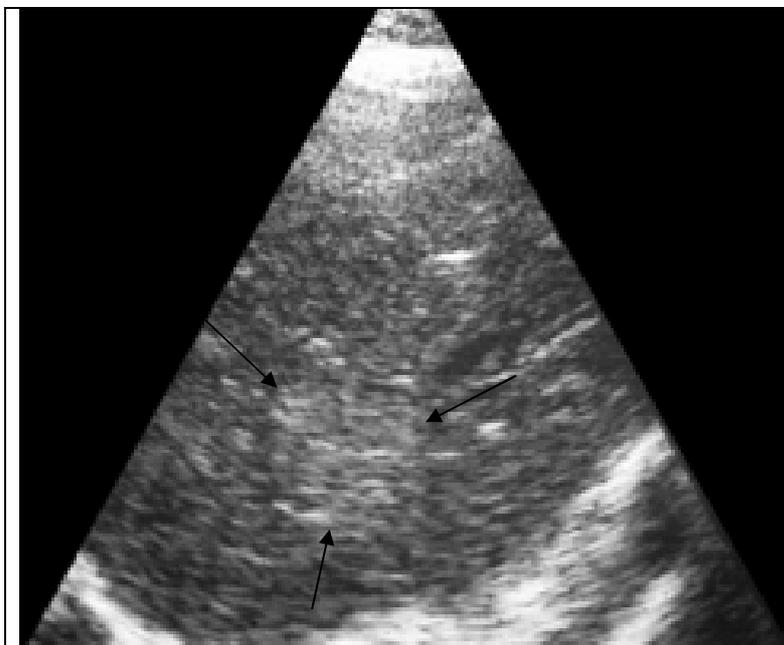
Ultrasound examination of the liver, revealing a hyperechoic lesion (diameter 3.5 cm) with irregular configuration and unsharp borders.
